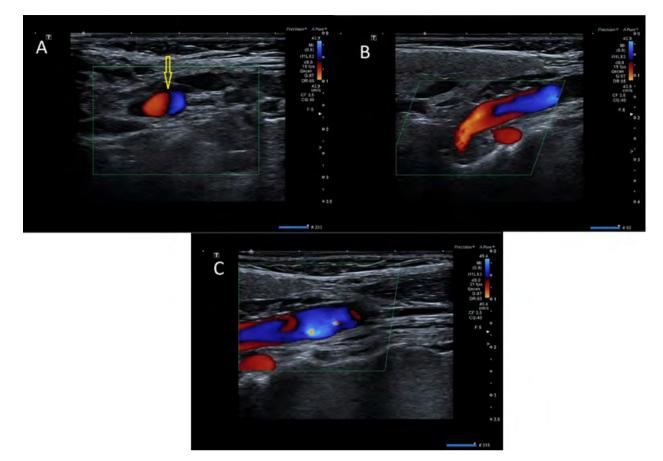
Duplex-doppler ultrasonography examination of RICA shows a dissection flap (yellow arrow [A]) separating the true and the false lumen. Retrograde flow is visible in the latter (B, C). The measured PSV value was 173 cm/s
